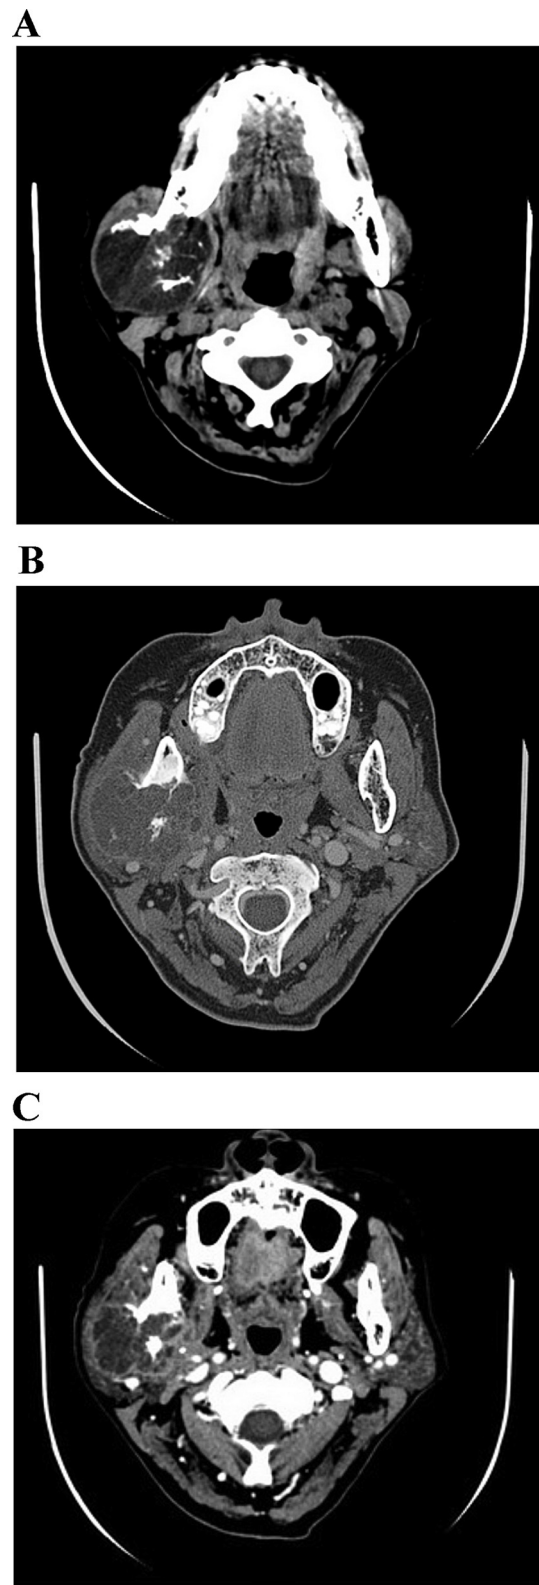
Axial non-contrast enhanced CT scan of the mandibular ramus shows a circumscribed margin, multilocular cystic mass at the right side with internal coarse, irregular calcifications (A). Bone window image reveals a very thin bone around the expansile mass (B). The tumor has contact surface with the right parotid gland and caused lateral displacement of the gland in a contrast enhanced film (C).
